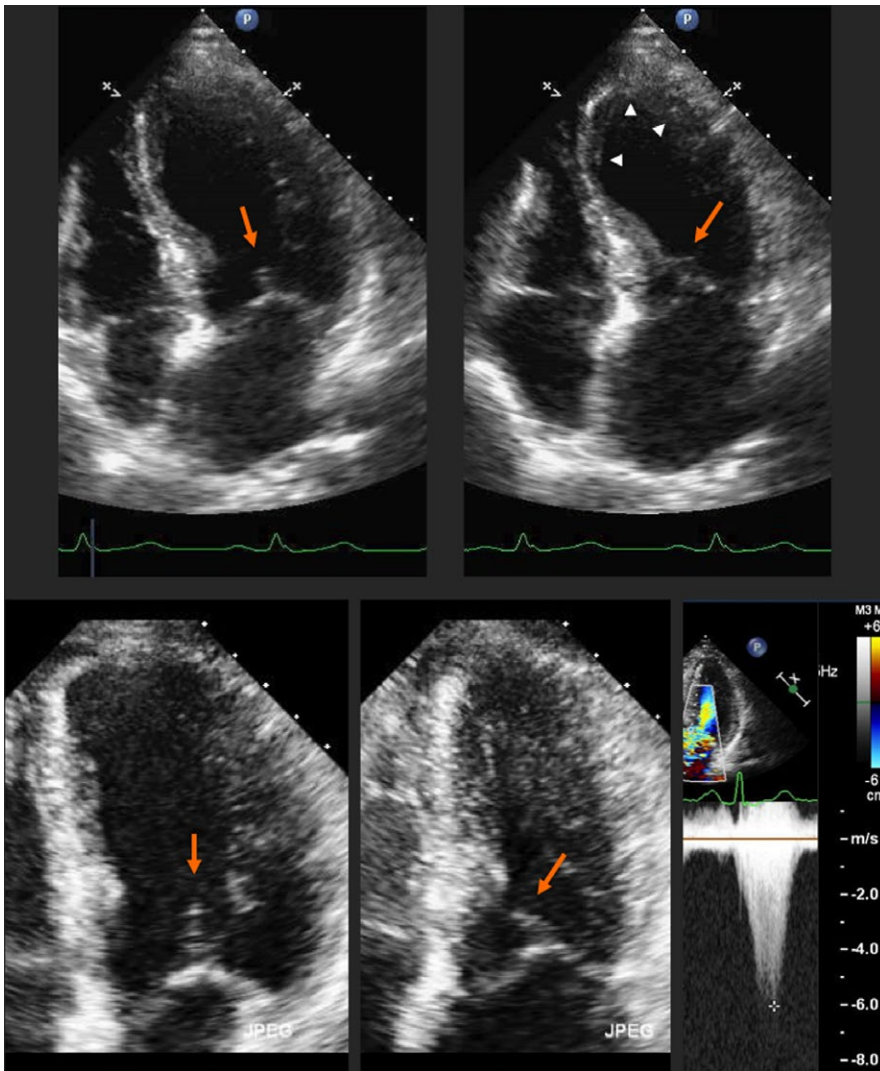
Three patients with mitral valve elongation mild septal hypertrophy and an episode of apical ballooning. Top 3 frames (A–C) show diastolic and systolic 3-chamber frames from the same patient at a time when LV systolic function was normal. A, Diastolic frame showing anterior mitral valve leaflet elongation 34 mm,  $20 \text{ mm/m}^2$  (elongated  $>16 \text{ mm/m}^2$ ).<sup>23–25</sup> B, Moment of coaptation. Protruding mitral anterior leaflet is shown by orange arrow. This pattern has been termed a “nightcap” mitral valve because of its characteristic appearance.<sup>16,46</sup> C, Early systole showing systolic anterior motion (SAM) of the mitral valve with the residual leaflet. There was no mitral-septal contact and no left ventricular outflow tract (LVOT) gradient. Such SAM can be a clue that LVOT obstruction is the cause of apical ballooning. Gradient was provoked by exercise echocardiography. Bottom, D–E, show systolic frames in another patient at the time of apical ballooning. D, “Nightcap,” protruding mitral leaflet at the moment of coaptation (orange arrow). Elongated anterior leaflet length in this patient was 34 mm,  $19.5 \text{ mm/m}^2$ . E, Later in systole. SAM of the mitral valve and mitral-septal contact. The white arrows in frames D and E show the ballooning akinetic apical septum. F: Apical 4-chamber view in another patient. Protruding mitral valve at the moment of coaptation
